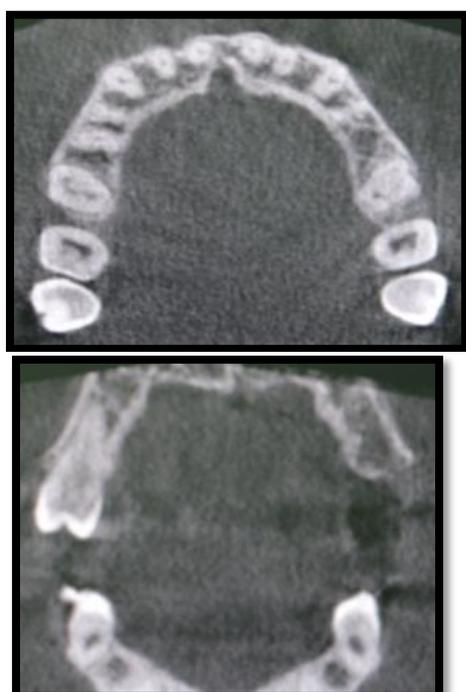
A CBCT scan coronal and axial view show the bone width, height and length.
